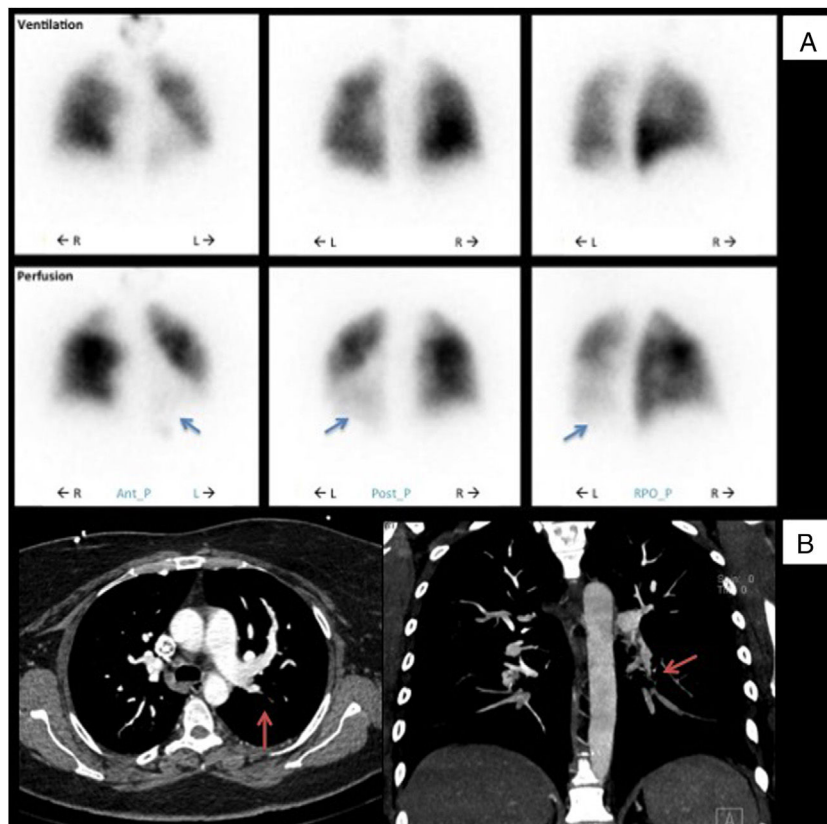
Initial diagnostic procedures. (A) Pulmonary ventilation/perfusion scan with subsegmental perfusion defects (blue arrows) and preserved ventilation in the left lower lobe; (B) computed tomography angiography with a subocclusive stenotic lesion at the origin of the left inferior lobar artery (red arrows). Ant_P: anterior-posterior; L: left; Post-P: postero-posterior; R: right; RPO_P: right posterior oblique-posterior.
